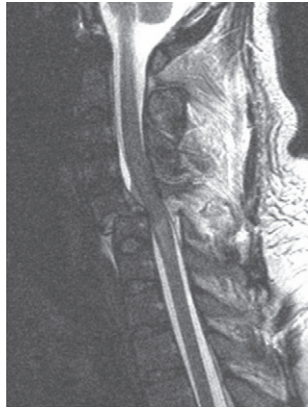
MRI T 2 WI showing cord edema more than 3 segments
